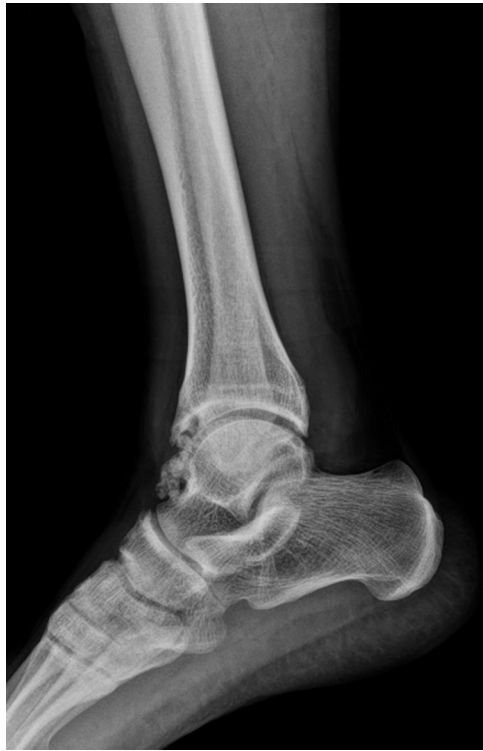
The lateral plain radiographic image of the ankle joint. Multiple calcified foci are seen on the anterior aspect of the ankle joint.
